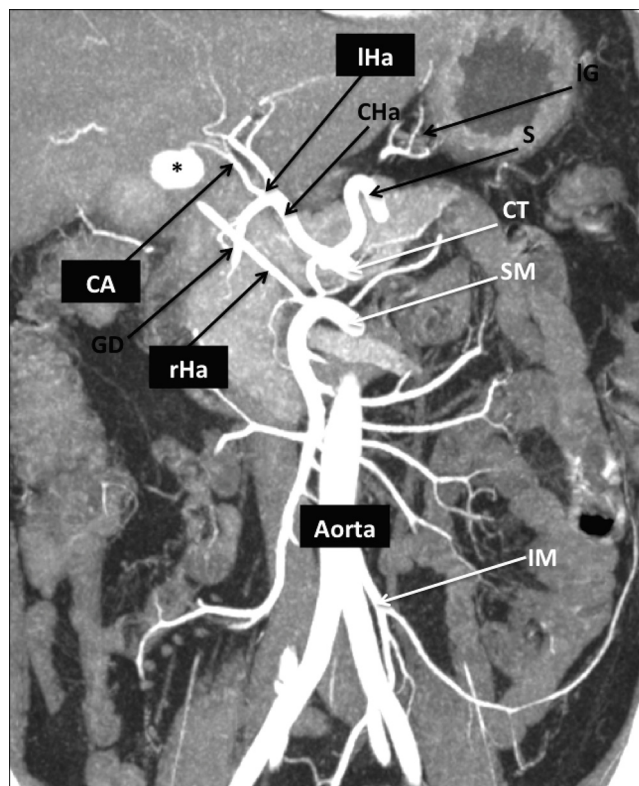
This coronal MIP post-processed computed tomography image clearly summarizes the particular vascular anatomy of our patient.
